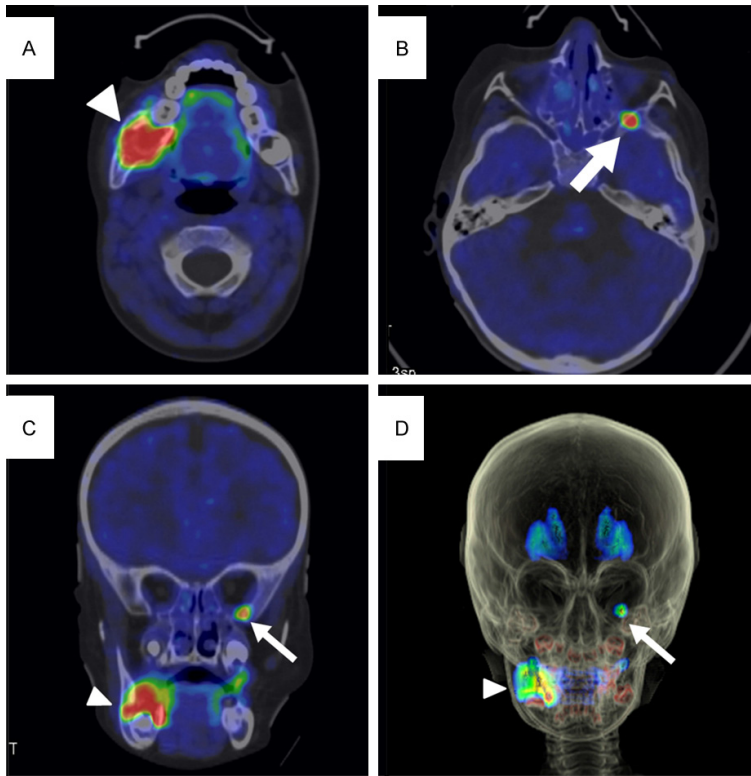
Axial (A and B), coronal (C) fusion PET/CT images and anterior view of 3D volume rendering fusion PET/CT image (D) showing high uptake of ^{18}F -DOPA in the right hemimandibula branch (arrowhead) and inferior orbital floor (arrow). Biopsy of the lesion in the right hemimandibula revealed bone metastasis from neuroblastoma.
